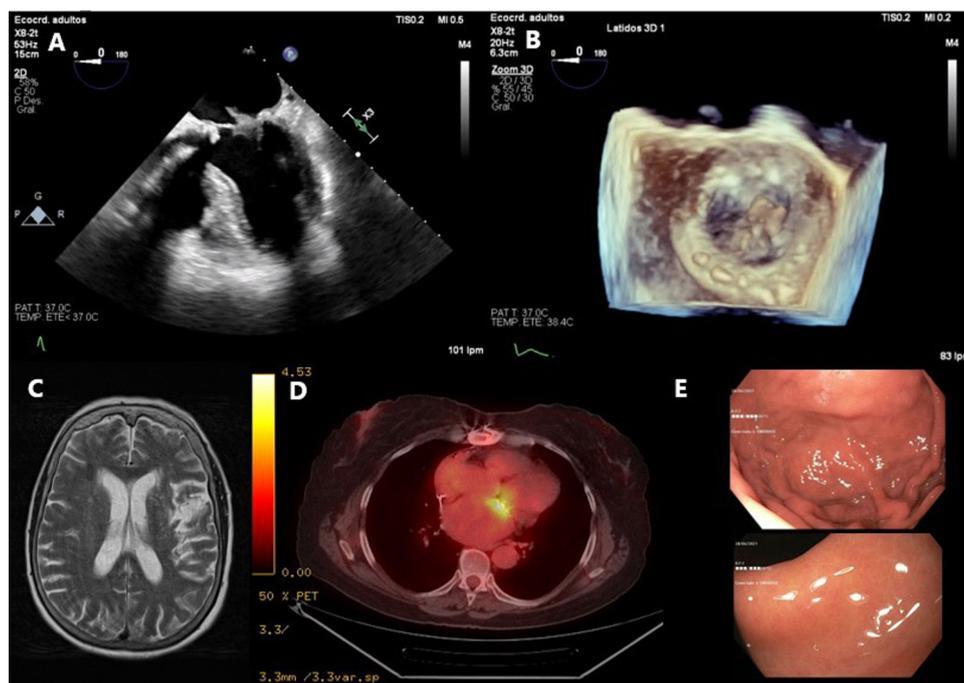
A: transesophageal echocardiogram at 0° showing a pedunculated lesion on the atrial side of the biological mitral valve prosthesis. B: 3-dimensional view of the lesion from the atrial side. C: cranial magnetic resonance imaging with residual left parietal ischemic lesion without septic embolism. D: positron emission tomography showing marked metabolic activity at the level of the prosthetic mitral valve. E: endoscopy with gastric (upper image) and duodenal (lower image) mucosa without erosions.
